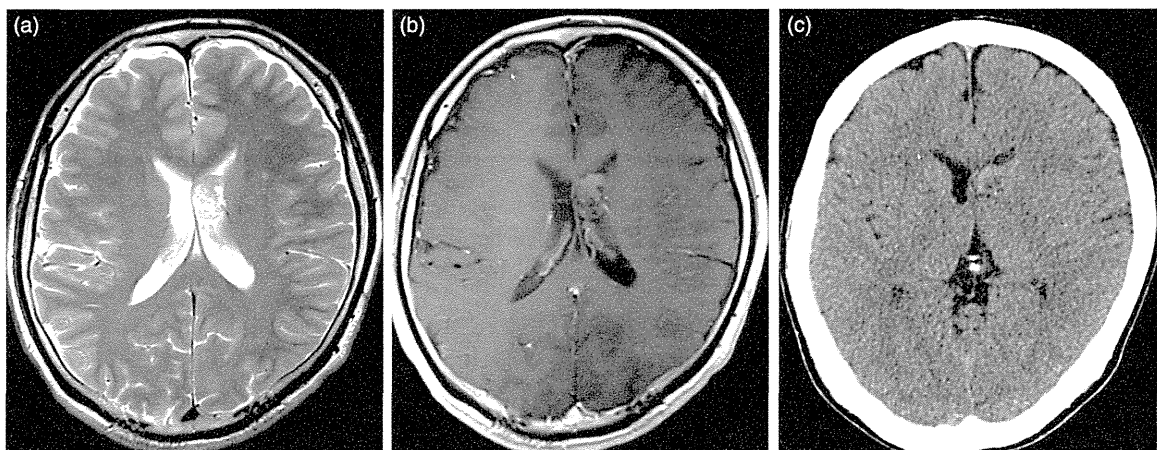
A representative case of a central neurocytoma located at the left lateral ventricle (patient 10). Diffusely distributed small cysts on T2W imaging (a) and moderately enhanced solid portion on contrast-enhanced T1W imaging (b) are noted. Calcification is not identified on CT (c).
